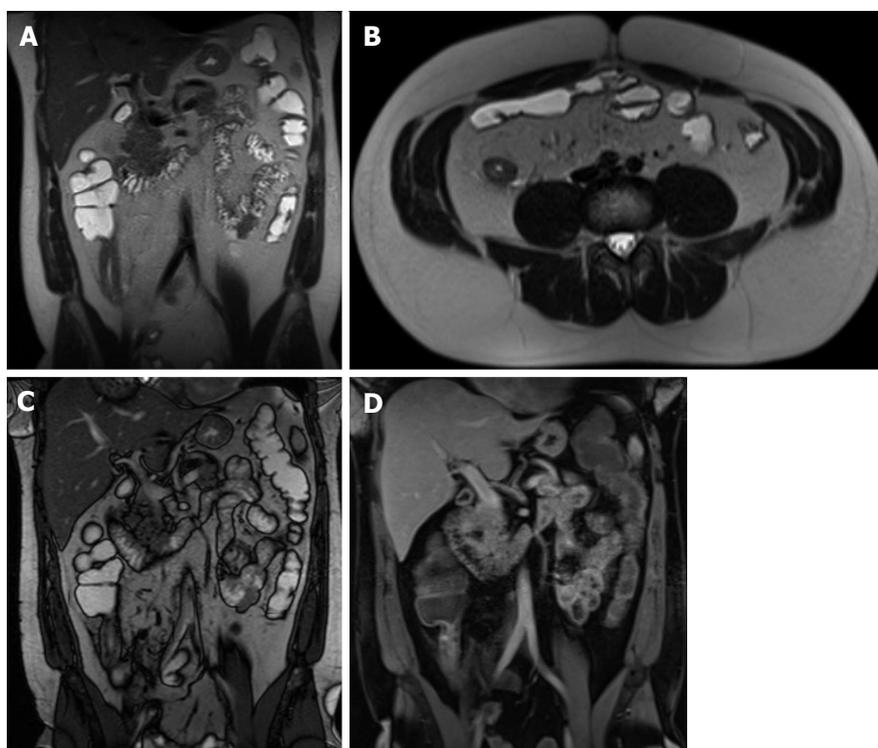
Recurrent Crohn's disease post-surgery. A: Coronal; B: Axial T2-weighted single shot fast spin echo images; C: Coronal balanced steady state free precession; D: Coronal fat suppressed post-gadolinium 3D-GRE T1-weighted images. The patient is post distal ileal resection with a low-lying ileocolic anastomosis. The remaining distal ileum displays signs of active inflammation, namely bowel wall thickening and submucosal edema (A and B) associated with mucosal and serosal increased enhancement post-gadolinium (D) in keeping with recurrent Crohn's disease post-surgery. GRE: Gradient recalled echo.
